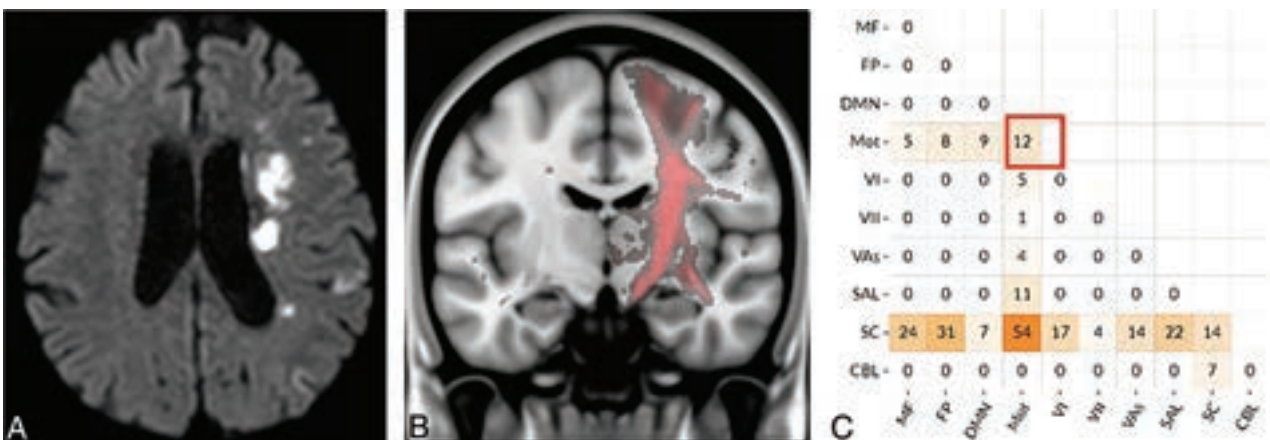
Representative case of a 39-year-old woman with left corona radiata ischemic infarction. The patient did not have poststroke dysphagia. She had disconnection in the motor network and not predicted correctly only by disconnection matrix (*C*, red square). However, the model incorporating both demographic variable and disconnection predicted correctly, maybe owing to the patient's relatively young age of 39. *A*, Left corona radiata infarction in DWI. *B*, Disconnected tract attenuation map (red) due to infarction. Substantial amount of the disconnection distributed in the motor network (*C*, red square); however, the prediction model incorporating both disconnection and age, sex could predict correctly.
